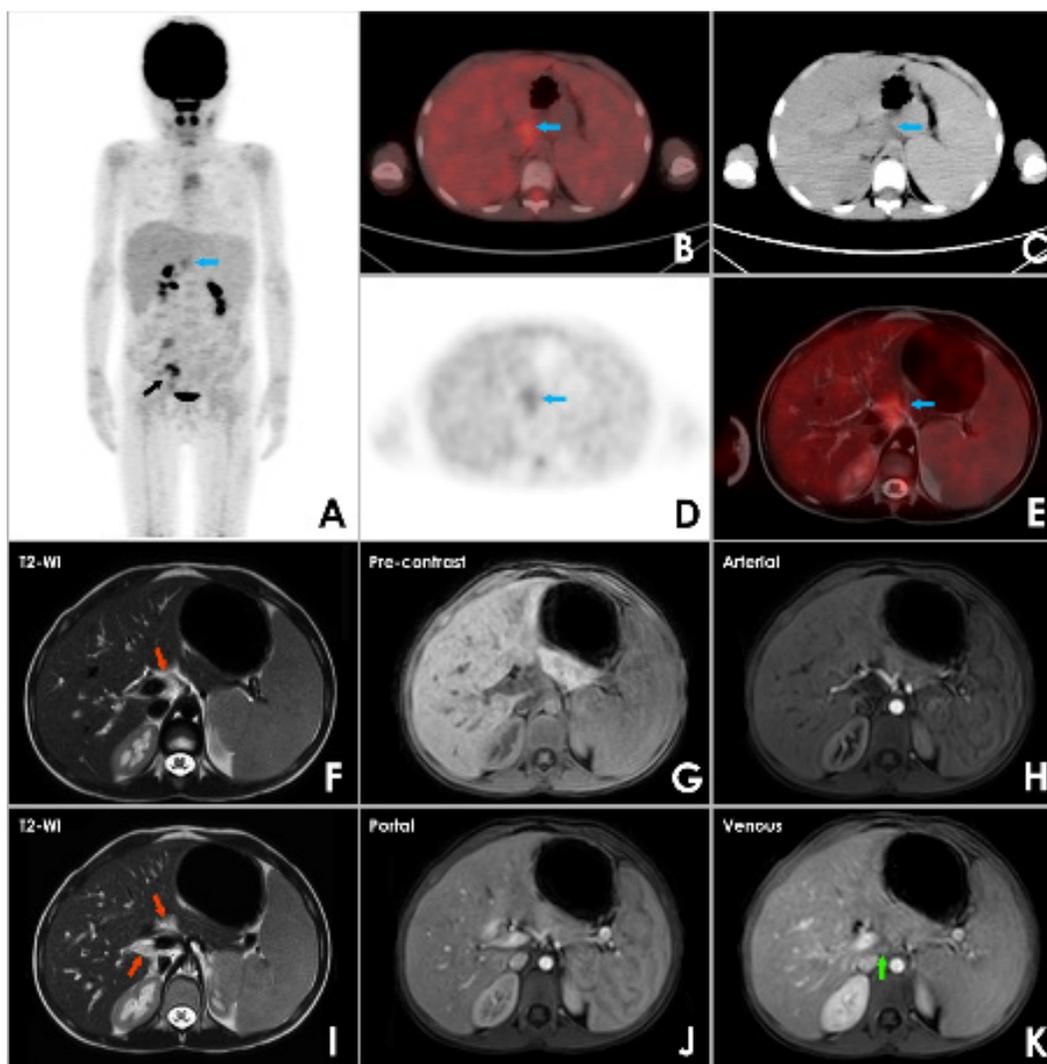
A 7-year-old boy with known diagnosis of hereditary spherocytosis and ulcerative colitis was referred for ^{18}F -fluorodeoxyglucose (^{18}F -FDG) positron emission tomography/computed tomography (PET/CT) after detection of a 28 mm lesion in spleen on upper abdomen magnetic resonance imaging (MRI). The lesion was hypointense on all MRI sequences and no pathological ^{18}F -FDG uptake was detected in PET/CT. Also, there was increased uptake localized to the right colon segment can be observed on MIP (A) in the right lower quadrant of abdomen (black arrow) which could be associated with ulcerative colitis. However, as an incidental finding, a moderately increased uptake (blue arrows) of ^{18}F -FDG was observed in periportal region on MIP (A) and transaxial (B, C, D) images with no definable mass. On the light of the ^{18}F -FDG PET/CT, retrospective evaluation of previous MRI revealed periportal hyperintensity (red arrows) on T2-weighted images (F, I) compatible with “periportal cuffing” as described on ultrasonography. Dynamic contrast-enhanced imaging (G, H, J, K) showed a progressive contrast enhancement (green arrow) in periportal area. Extrahepatic biliary system was normal and magnetic resonance cholangiopancreatography findings were negative for the primary sclerosing cholangitis. On fusion images of PET/CT and T2-weighted images (E) it can be clearly seen that increased ^{18}F -FDG uptake on periportal region corresponds to periportal hyperintensity on MRI.
